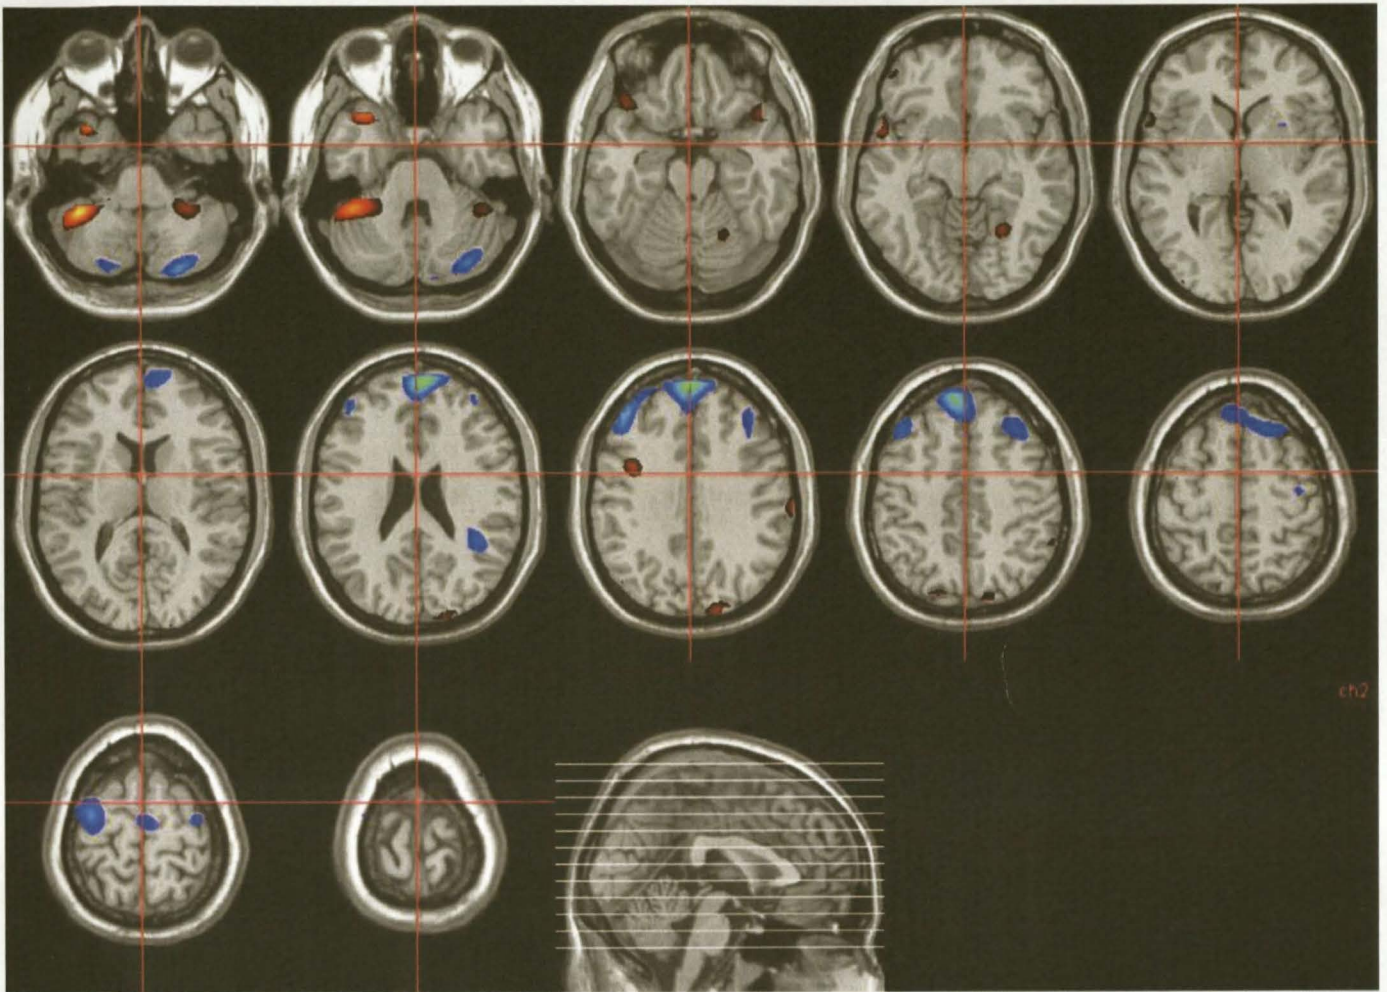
Selected Axial SPECT Slices co-registered to MRI showing Changes in rCBF in Patient 4, before and after Treatment.
